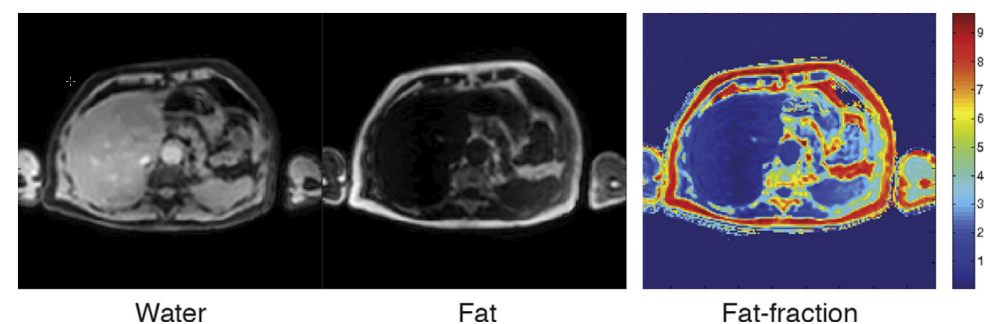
DIXON MRI of the liver to quantify hepatic triglyceride content. The left and middle images are the reconstructed water and fat images, respectively. A 6-point DIXON sequence was used with a starting echo time of 0.74 ms and echo spacing of 1 ms. The fat fraction
